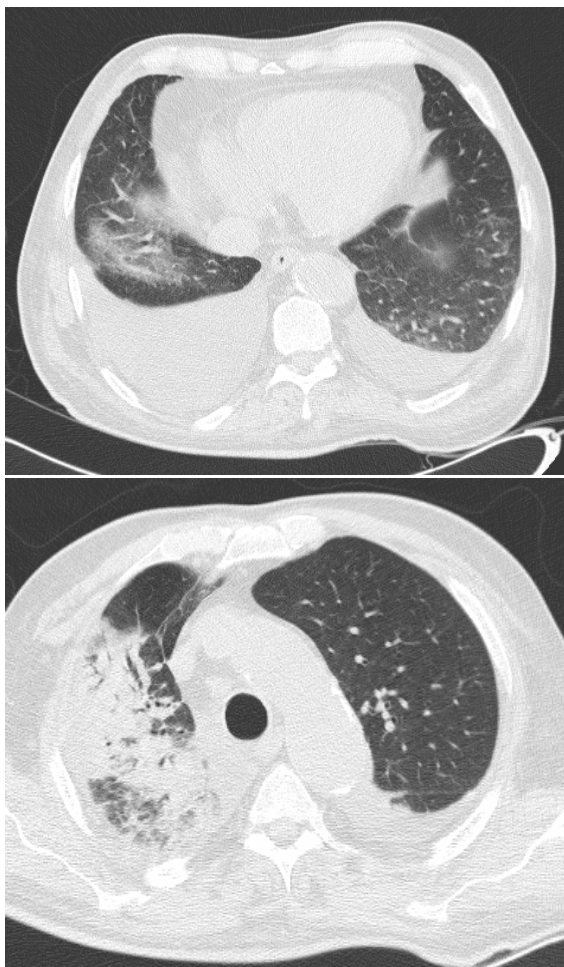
Chest CT-scan on admission in intensive care unit revealed increased alveolar infiltration and bilateral pleural effusion.
